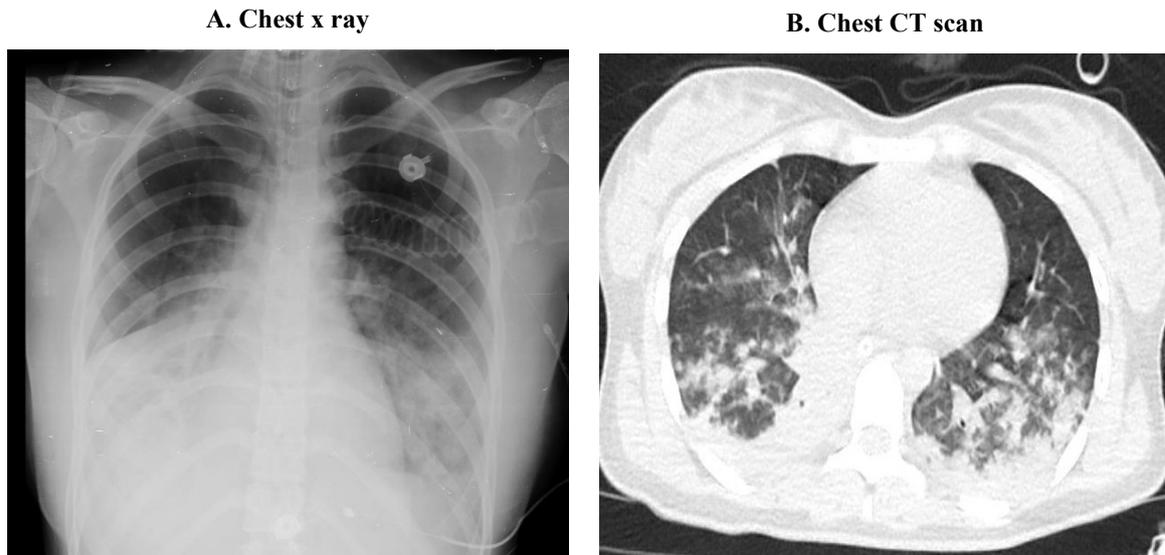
Chest X-ray and non-contrast chest computed tomography (CT) scan of the patient (Prepared by Authors, 2025).
